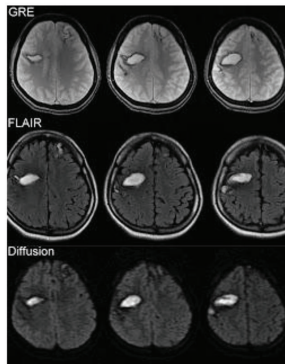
MR appearance of ICH: (Top) MRI shows a focal left parietal para sagittal bleed with low signal intensity (yellow arrowhead) on T2*GRE (image C), T1 and T2 (A & B) show a bright hyper-intensity (red arrowhead) due to Meth Hb, a blood degradation product indicating a sub-acute bleed. (Bottom) MRI showing sub-acute hematoma with restricted diffusion.
